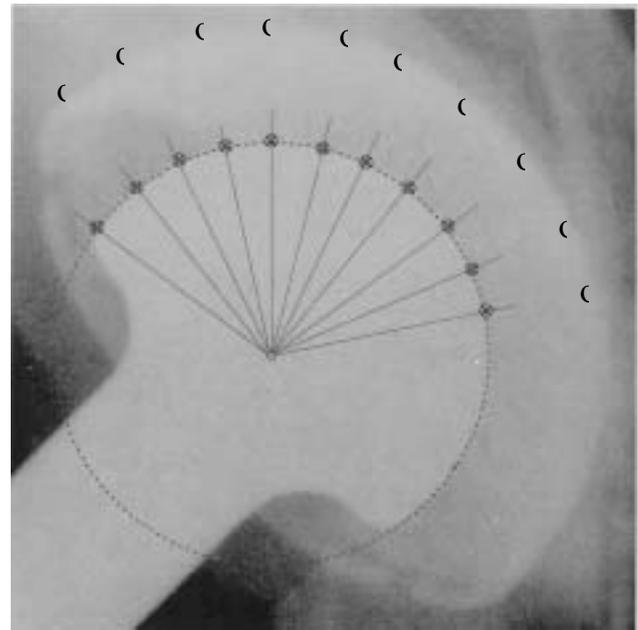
Application of digital edge detection to measure THA wear radiographically. Search rays are computationally generated at 0.5° increments (here, for clarity, rays are displayed only at 10° increments). The pixel grayscale gradient is calculated at each point along each ray. The points of maximal gradient (denoted by the "f" symbols for the femoral head and the "o" symbols for the cup backing) identify the respective component margins. Ellipses are least-squares best fit to these two sets of points, to determine the apparent penetration of the femoral head into the acetabular component. Doing this at follow-up, and subtracting the corresponding measurement postoperatively, allowed assessment of interval wear between those two time points.^{51,52,53}
